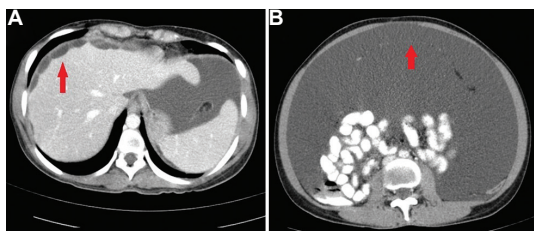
(A) Contrast-enhanced axial computed tomography images showing loculated ascites with multiple thin septae, scalloping of the liver (arrow) and (B) mild omental thickening (arrow).
